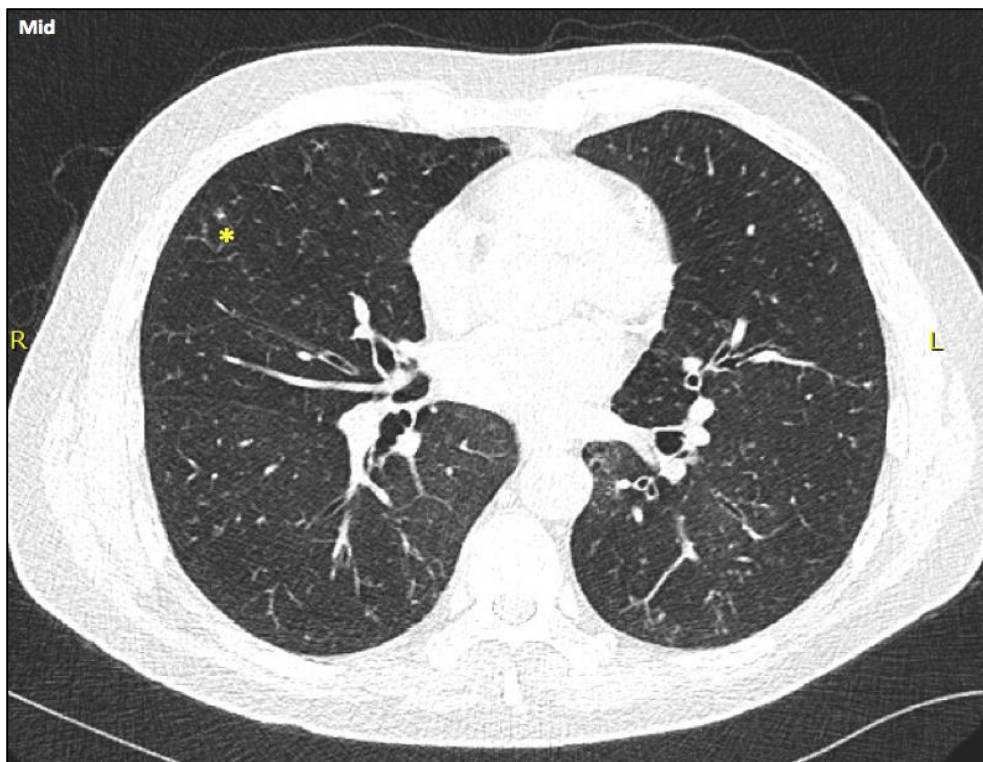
Computed tomography: Diffuse nodularity particularly in the right middle lobe with sparse tree in bud (*). Patchy ground glass changes
